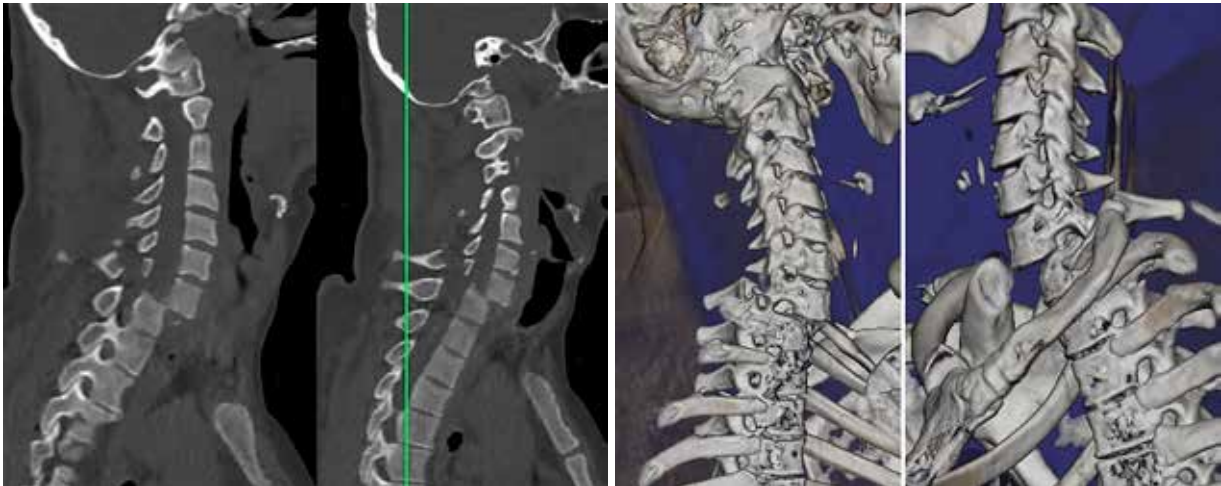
Spiral computed tomography of the cervical spine before surgery
